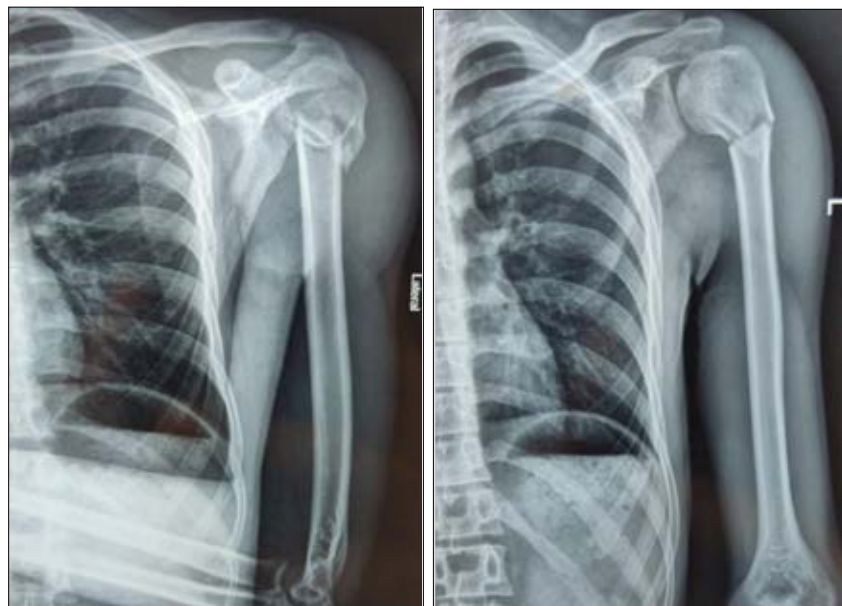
Pre operative radiographs of case 2: 23 year old male with left 2 part proximal humeral fracture.
